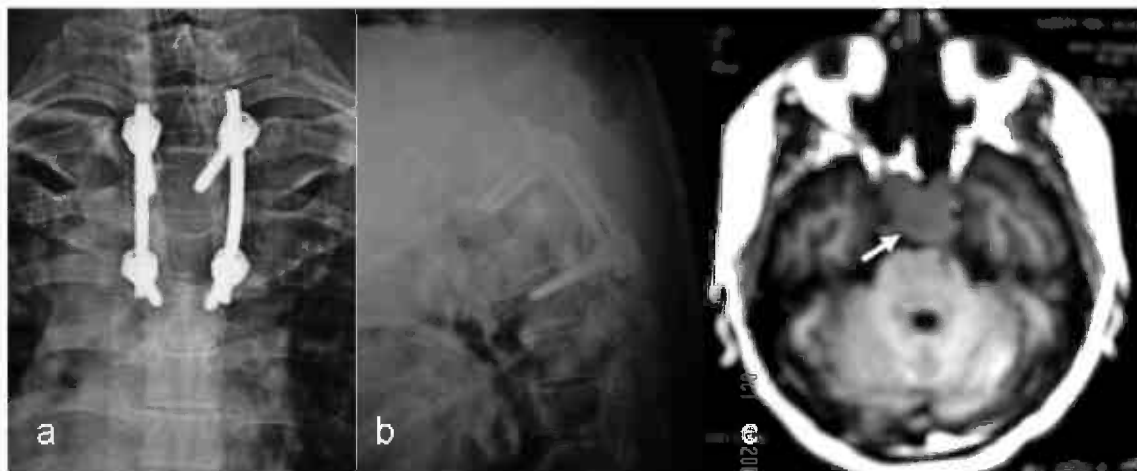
Sixth month follow-up. (a) Antero-posterior and (b) lateral radiographs show posterior decompression and instrumentation. (c) Axial T1-W MR image shows soft tissue marrow replacement in the body of the sphenoid bone (arrow).
